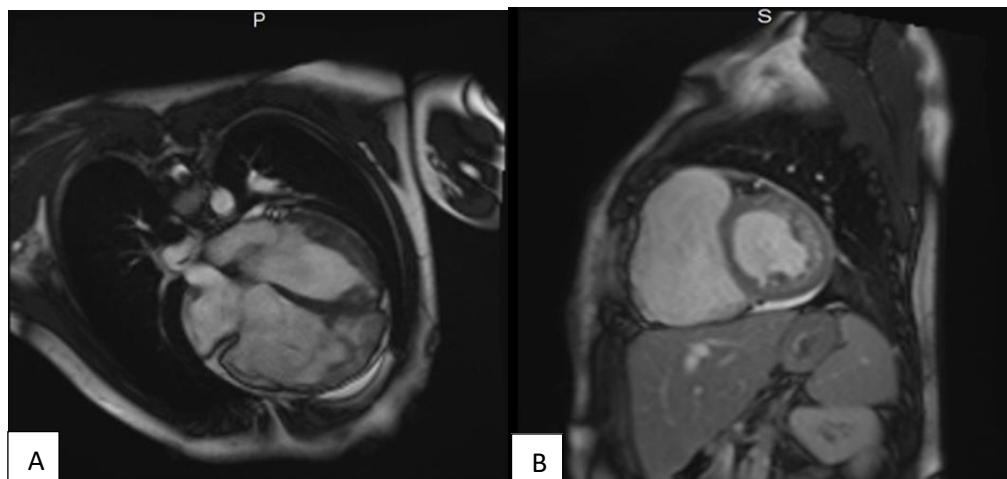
(A and B): MRI of the heart of patient 2 with fibrosis fields were detected in the myocardium. Significant dilation of the right ventricle, right atrium, moderate dilation of the left ventricle was observed.
